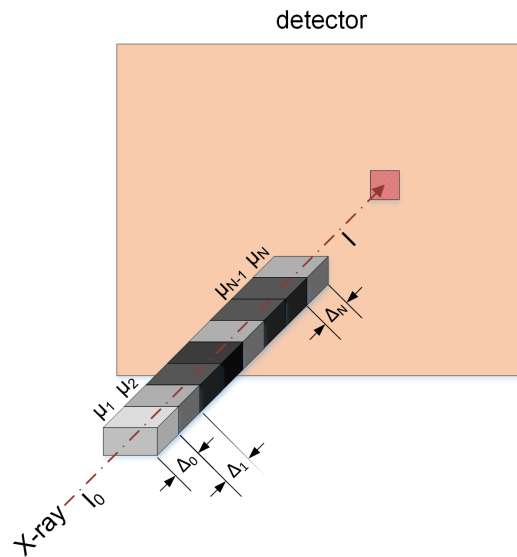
A detector element (pixel) measures the remaining X-ray intensity after being attenuated by the materials (μ_i crossed by the said X-ray. The X-ray has an initial intensity I_0 .
